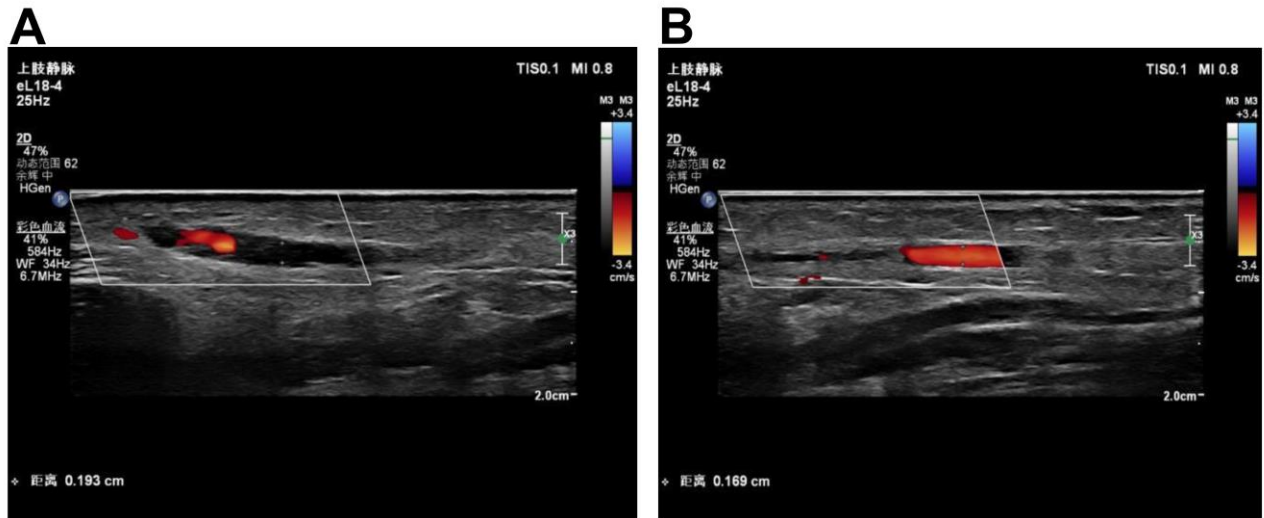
Color Doppler ultrasound analysis of veins in cases with moderate venous injury vascular wall after removal of peripheral venous indwelling needles. (A) Within 24h after needle removal, the vascular wall was thickened, the lumen diameter was slightly expanded to 1.9mm and there was mural thrombosis. Moderate venous injury was diagnosed. (B) On day 4 after needle removal, the thickening of the vein wall was reduced and the lumen diameter was restored to 1.69 mm, but it was still in a slightly dilated state and the thrombus was not dissolved. Moderate venous injury was diagnosed.
